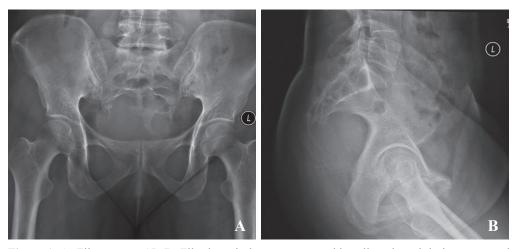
A: Film sacrum AP, B: Film lateral, the mass was accidentally palpated during an annual gynecological examination. From plain radiographs showing a large soft tissue mass with extensive osteolytic lesion with its epicenter at the sacrum.
